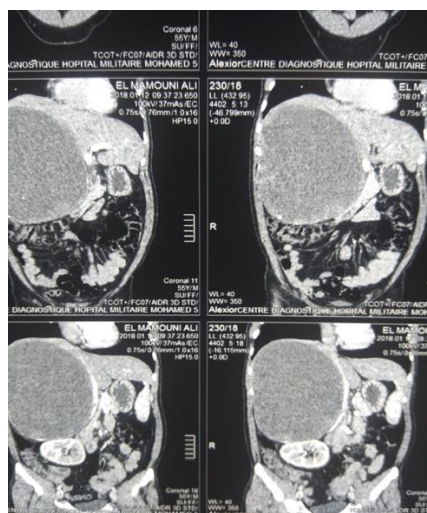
Sagittal CT section showing the right adrenal mass.
